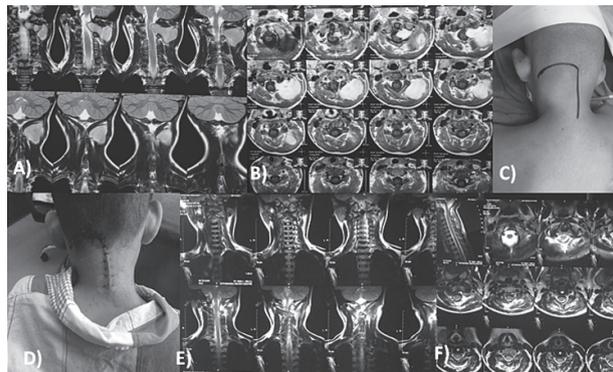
A, B) Preoperative MRO TIW with contrast Coronal and Axial view showing giant dumbbell schwannoma at C2 level on left side, C) intraoperative position and incision mark, D) post operative wound, E, F) post operative MRI showing complete excision of mass
